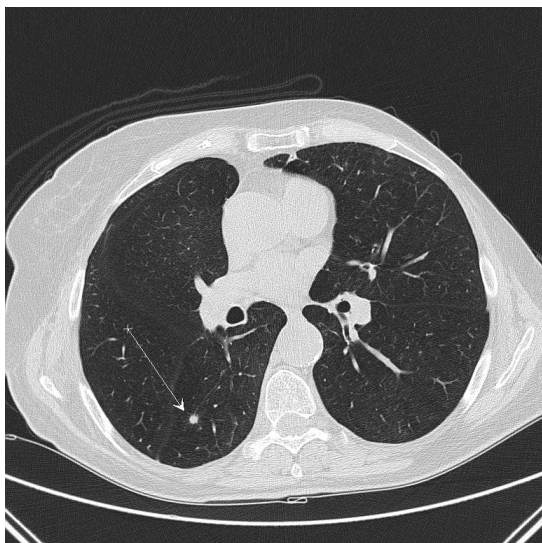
Computed Tomography (CT) scans of lung metastasis of breast cancer in a 63-year-old patient. She has received five cycles Xeloda mono-chemotherapy and no change was established.
